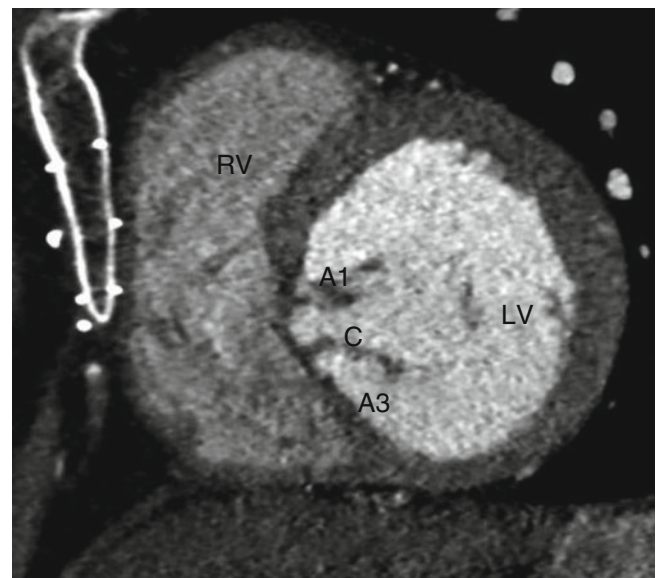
Cleft mitral valve. In this short-axis computed tomographic angiogram, the anterior leaflet contains a cleft such that the A2 segment is absent and the cleft is present in its place. *A1* A1 segment, *C* cleft, *A3* A3 segment (Image kindly provided by Anthony Hlavacek, MD, Medical University of South Carolina). *RV* right ventricle, *LV* left ventricle
